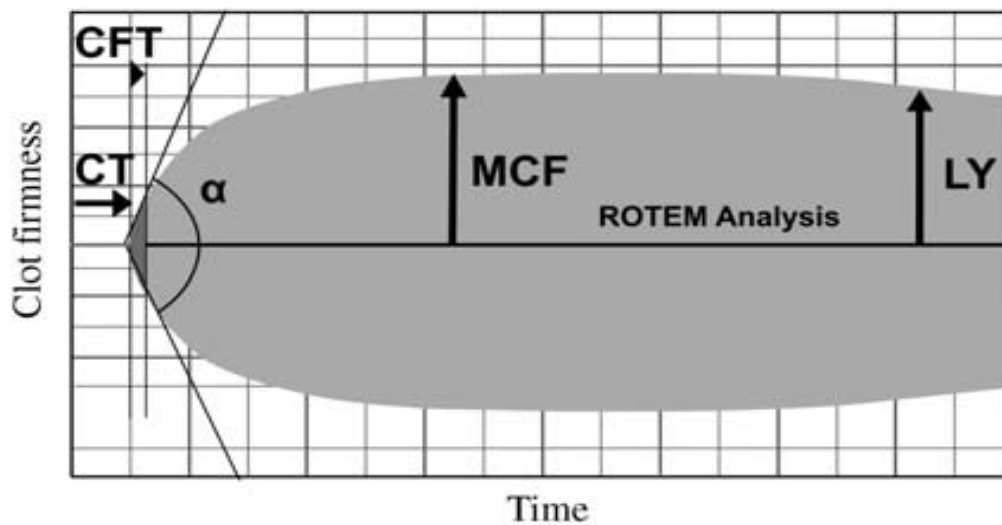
Thrombelastometry (ROTEM®) tracing. α : alpha angle; CFT: clot formation time; CT: clotting time; LY: clot lysis; MCF: maximum clot firmness.
